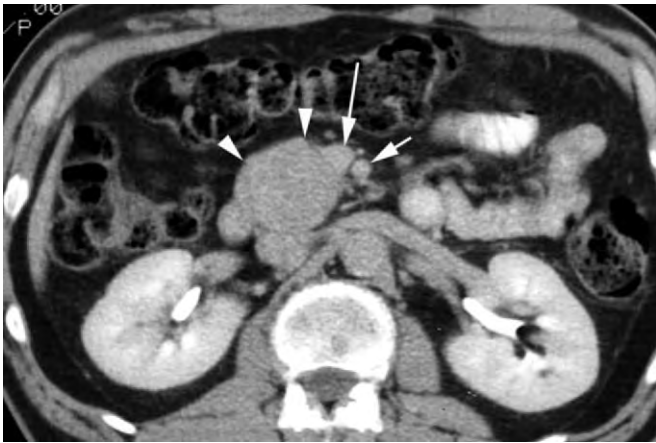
Axial contrast-enhanced CT scan shows a pancreatic head mass (*white arrowheads*) identified on surgical pathology as lymphoma. The *long white arrow* indicates the superior mesenteric vein and the *short white arrow* points out the superior mesenteric artery.
